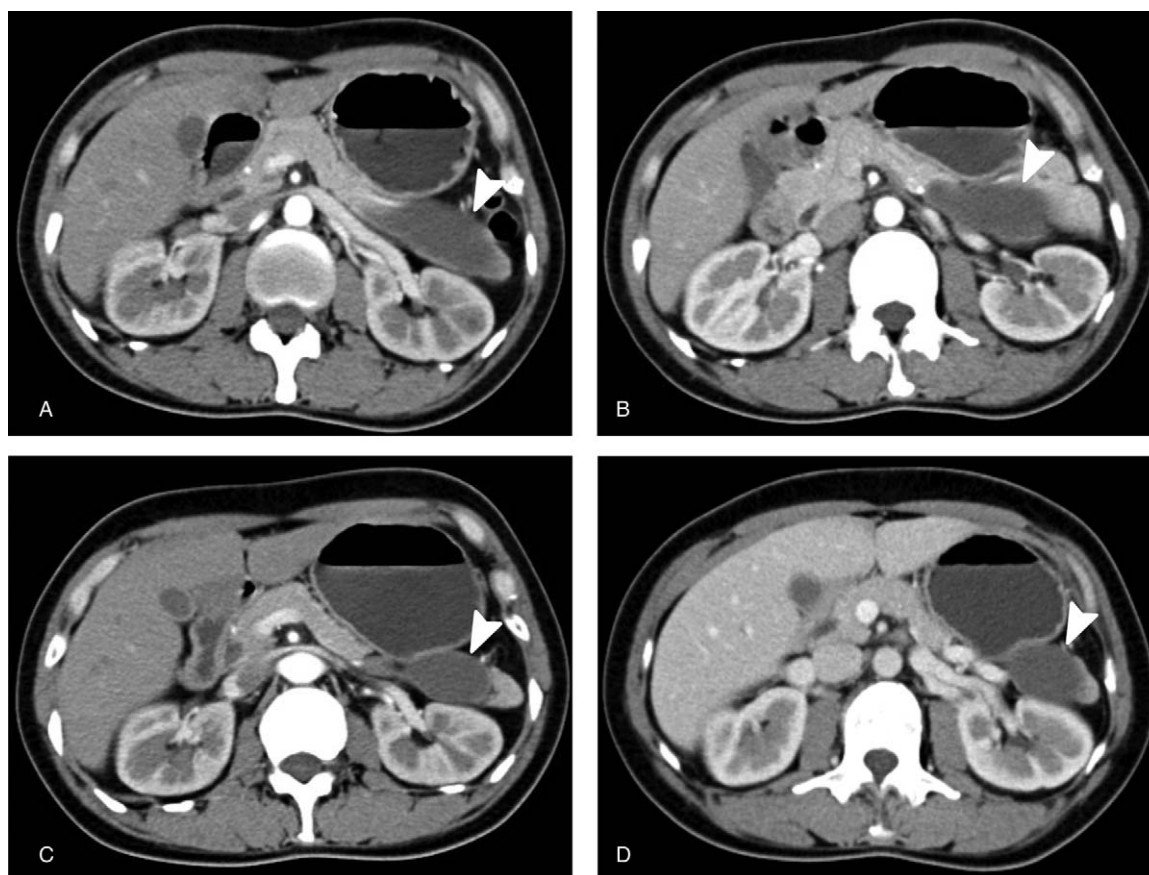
Contrast-enhanced CT during 5 years of surveillance. 2012-10-26 (A); 2013-06-17 (B); 2014-09-16 (C); 2017-09-07 (D). (A–D) Four images at different periods of time manifested as an irregularly-shaped cystic lesion without enhancement, which had a very close relationship with pancreas from the view of the transverse, and it was misdiagnosed with a cystic pancreatic lesion in the first 3 times. During follow-up, the shape of the lesion significantly changed, which may be a distinctive expression of the ciliated foregut cyst. CT=computed tomography.
